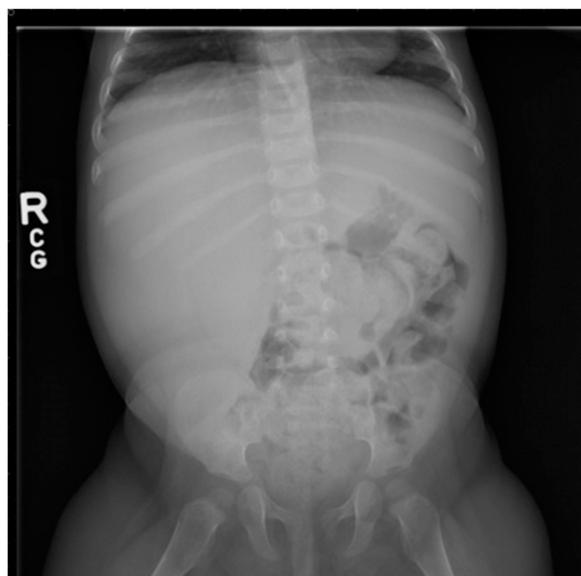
Abdominal plain radiograph showing hepatomegaly and centrally displaced loops of bowel.
